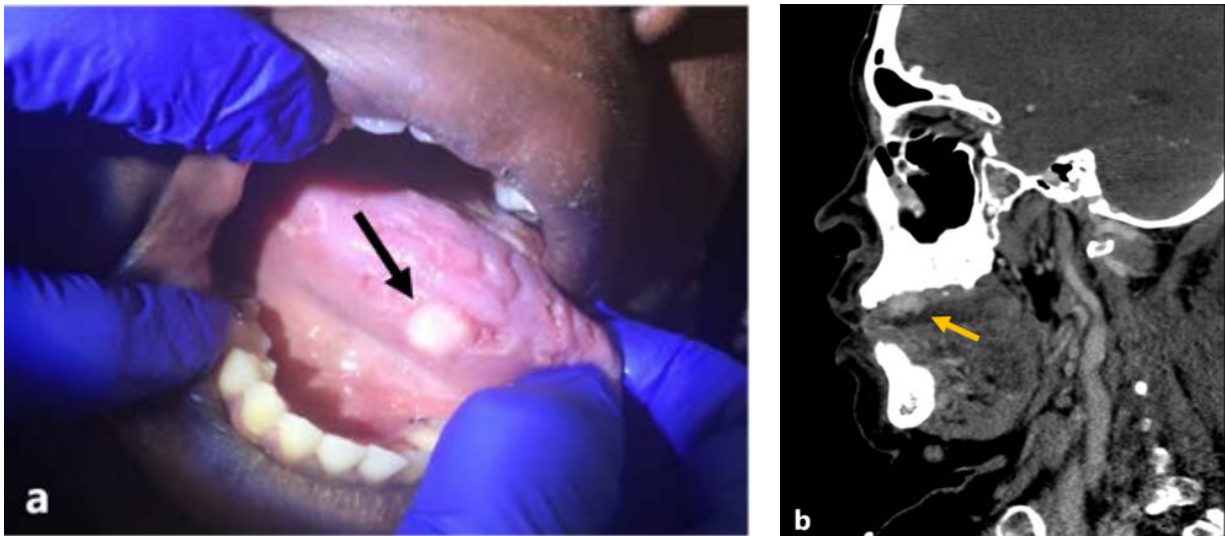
A 36-year-old female with granular cell tumor of the tongue (5a). Sagittal contrast-enhanced CT neck study revealed a non-specific homogeneously enhancing mass which is indistinguishable from tongue cancers (5b).
